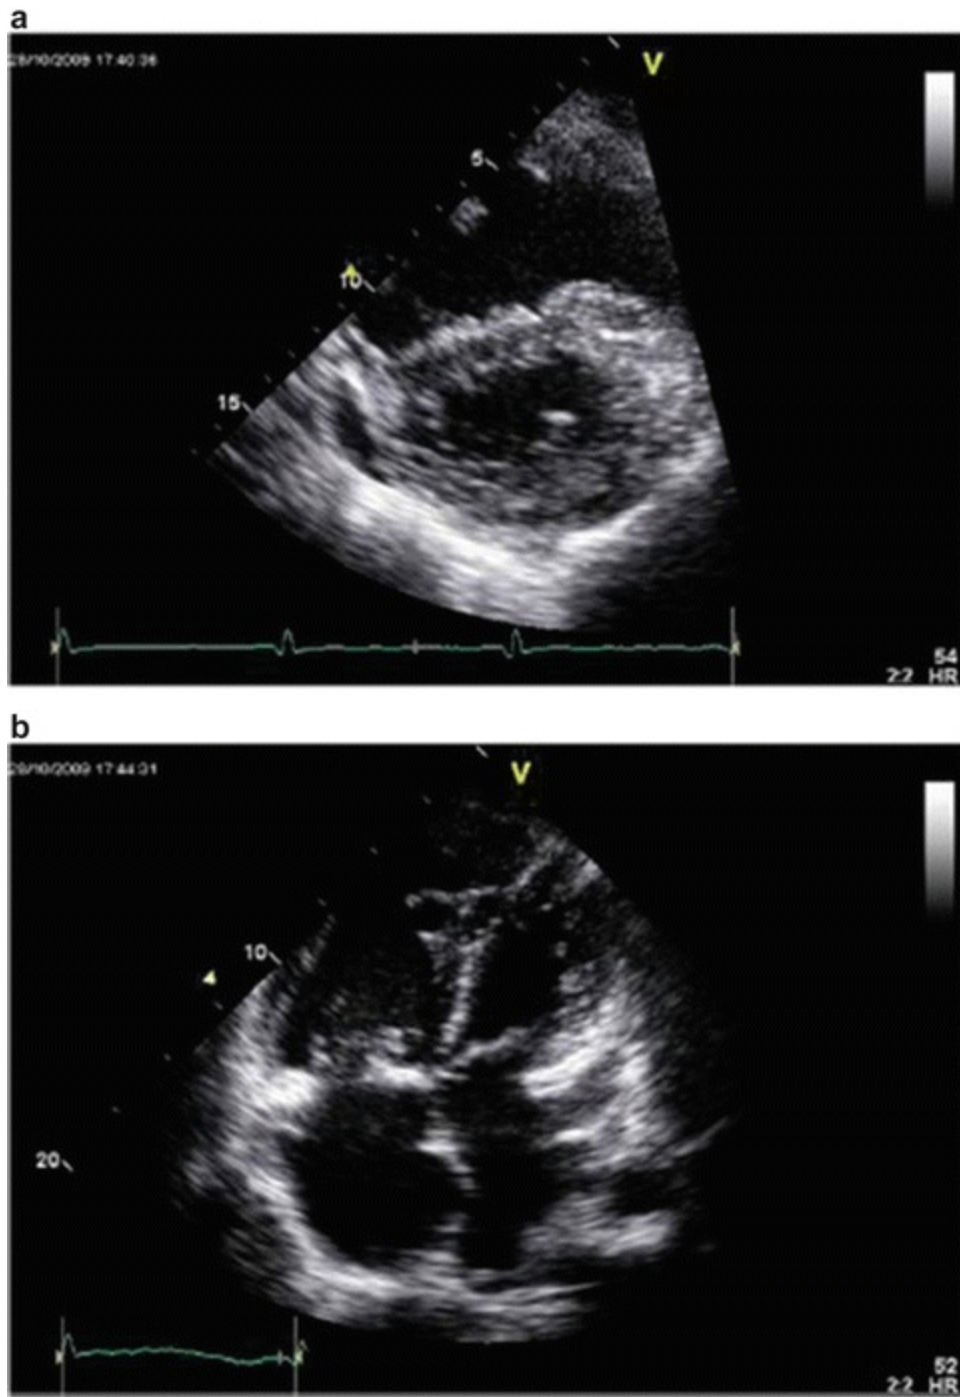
Transthoracic echocardiographic images of a patient with portopulmonary hypertension. Note the D-shaped left ventricle in the short-axis view (a) and a severely dilated right ventricle in the four-chamber view (b)
